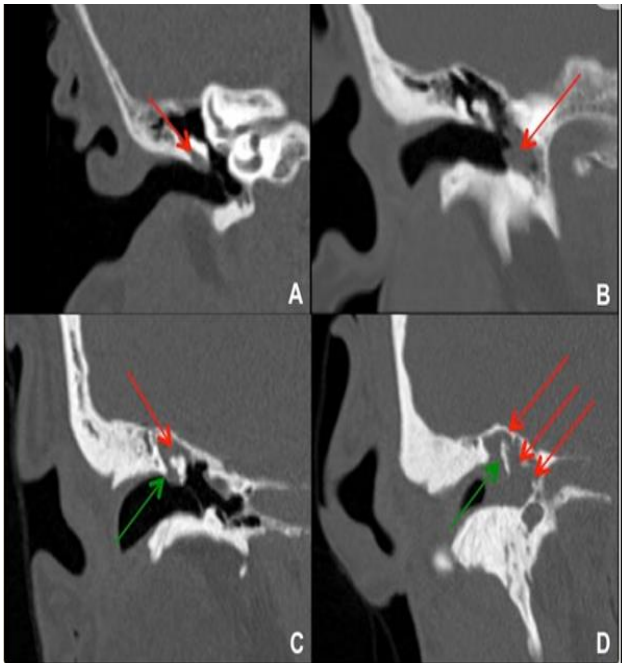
(A-D): Coronal images from temporal bone CTs in four different patients with right cholesteatoma. Small cholesteatoma in Prussak's space (red arrow) without bony erosion. This is a common site for pars flaccida retraction and acquired cholesteatoma formation. Cholesteatoma in the left mesotympanum to hypotympanum (red arrow), which is a less common site. Cholesteatoma in the right epitympanum (red arrow) with blunting or erosion of the right scutum (green arrow). This lesion probably started in Prussak's space adjacent to the bony scutum. Large cholesteatoma in the right epitympanum, mesotympanum, and hypotympanum (red arrows), with bony erosion of the scutum and malleus/ossicles (green arrow). Axial CT through the mesotympanum shows the sinus tympani (yellow arrow) and facial recess (white arrow) which are hidden areas by otological examination and should be carefully inspected on imaging for the presence of soft tissue.
